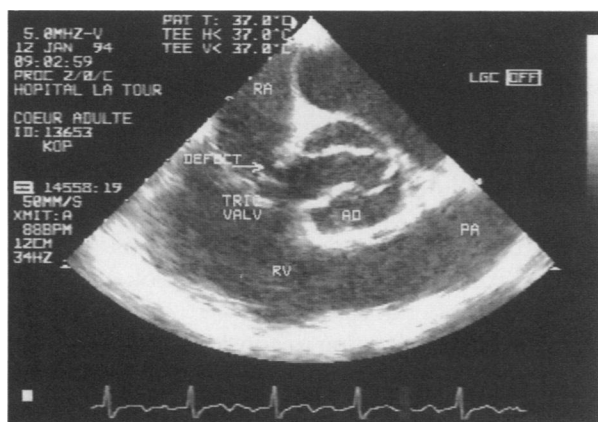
Transesophageal echocardiogram showing a subaortic ventricular septal defect with flow both to the right atrium and to the right ventricle.
